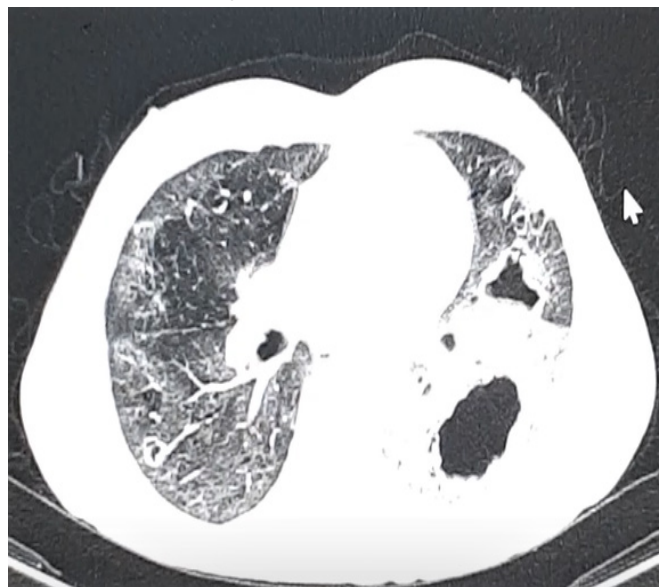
Repeat Chest CT showing cavity at the left lower lobe with ground glass opacities.
